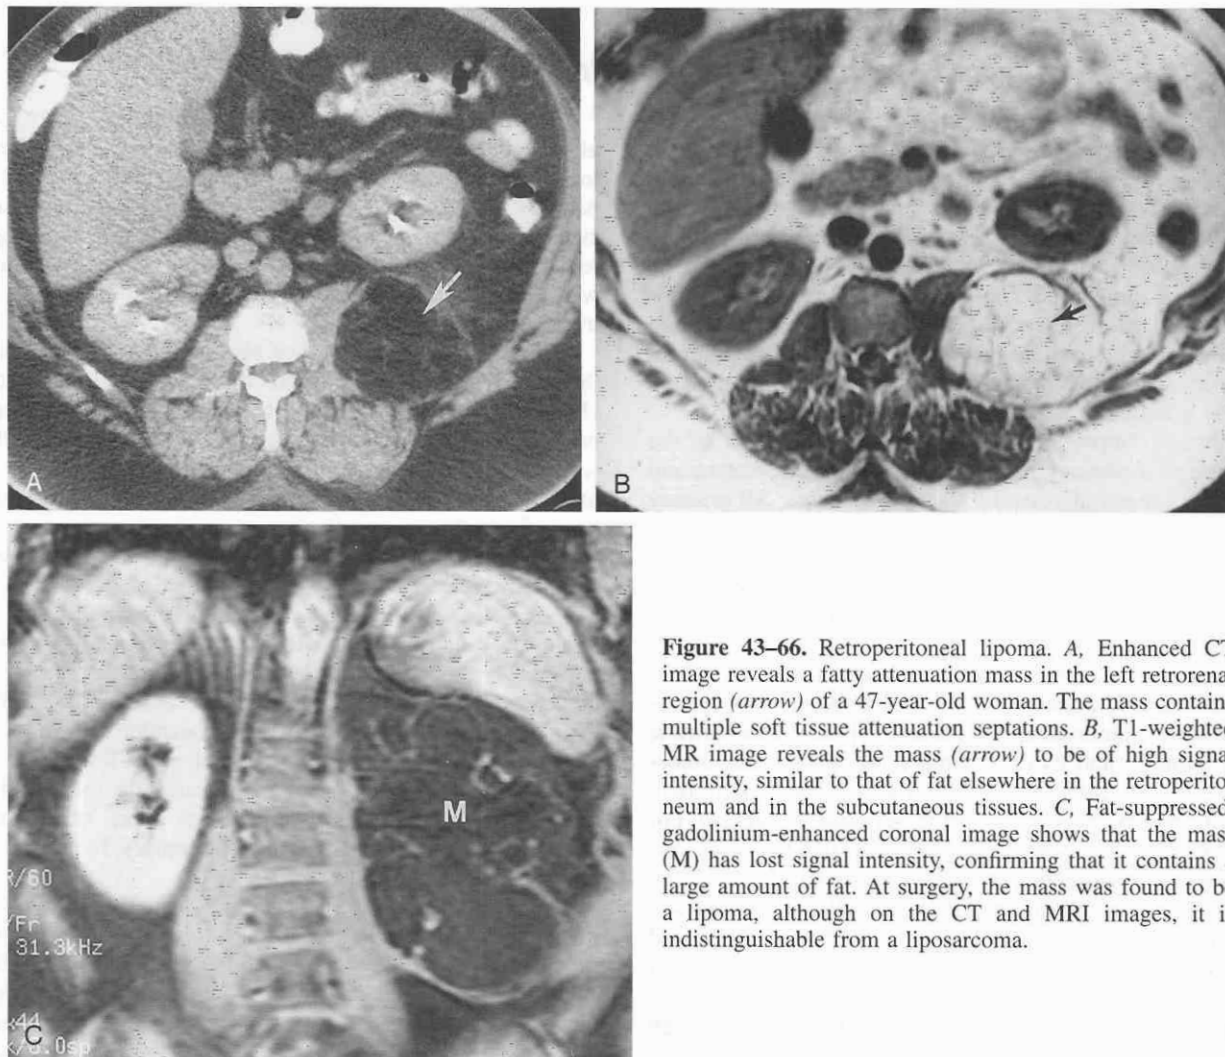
Retroperitoneal lipoma. *A*, Enhanced CT image reveals a fatty attenuation mass in the left retrorenal region (*arrow*) of a 47-year-old woman. The mass contains multiple soft tissue attenuation septations. *B*, T1-weighted MR image reveals the mass (*arrow*) to be of high signal intensity, similar to that of fat elsewhere in the retroperitoneum and in the subcutaneous tissues. *C*, Fat-suppressed, gadolinium-enhanced coronal image shows that the mass (*M*) has lost signal intensity, confirming that it contains a large amount of fat. At surgery, the mass was found to be a lipoma, although on the CT and MRI images, it is indistinguishable from a liposarcoma.
